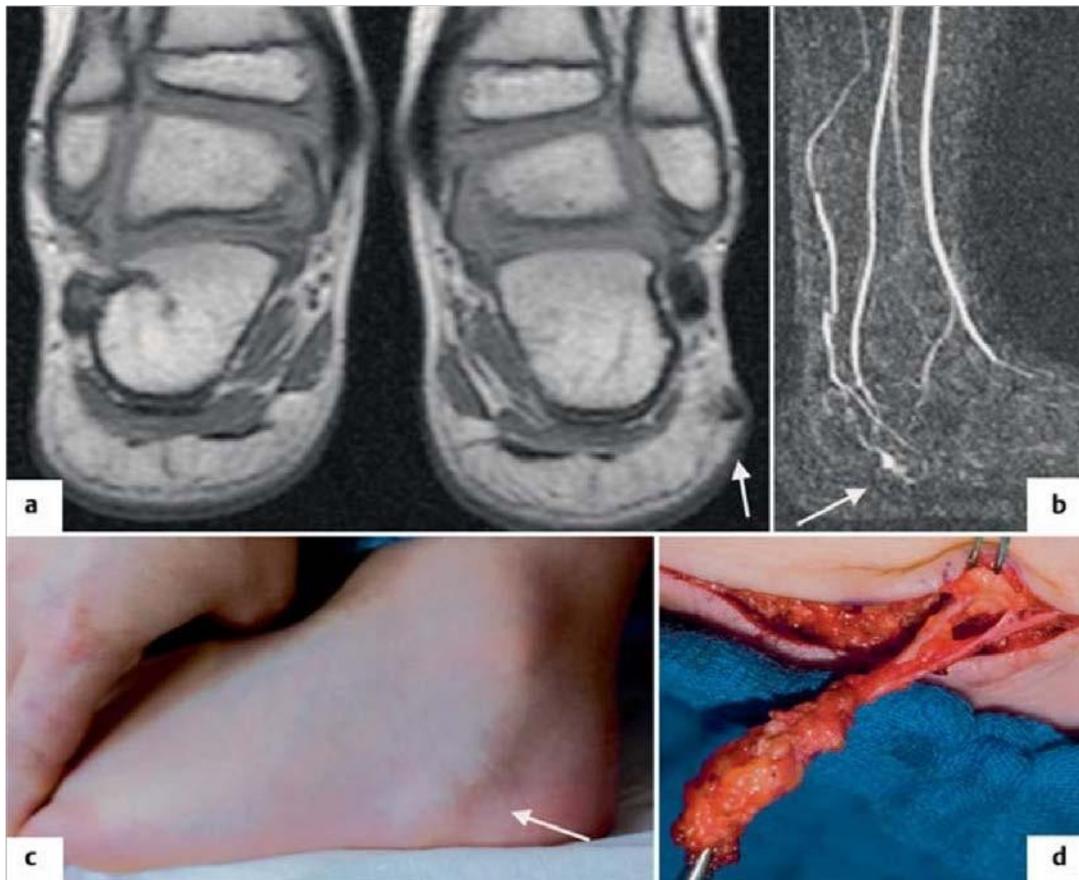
a,b,c,d. Child 8 years old with painful pulsating swell at the lateral edge of the heel (c), magnetic resonance imaging showed an arteriovenous malformations (a,b) which was surgically completely resected (d).
